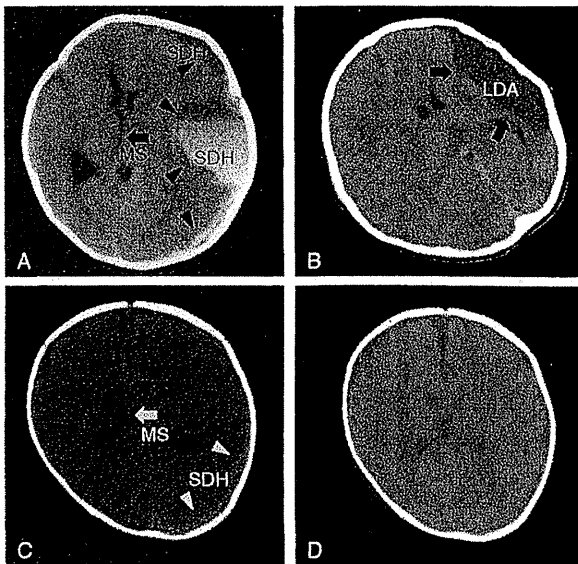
Comparison of head computed tomography (CT) scans at admission and during follow-up. A, Head CT of case 6 at admission, showing subdural hemorrhage (SDH) (arrowhead) and midline shift (MS) (arrow). B, Head CT of case 6 during follow-up, showing low-density area (LDA) consistent with encephalomalacia in the left hemisphere without new hemorrhage (arrow). C, Head CT of case 7 at admission, showing SDH (arrowhead) and MS (arrow). D, Head CT of case 7 during follow-up, showing no abnormalities.
